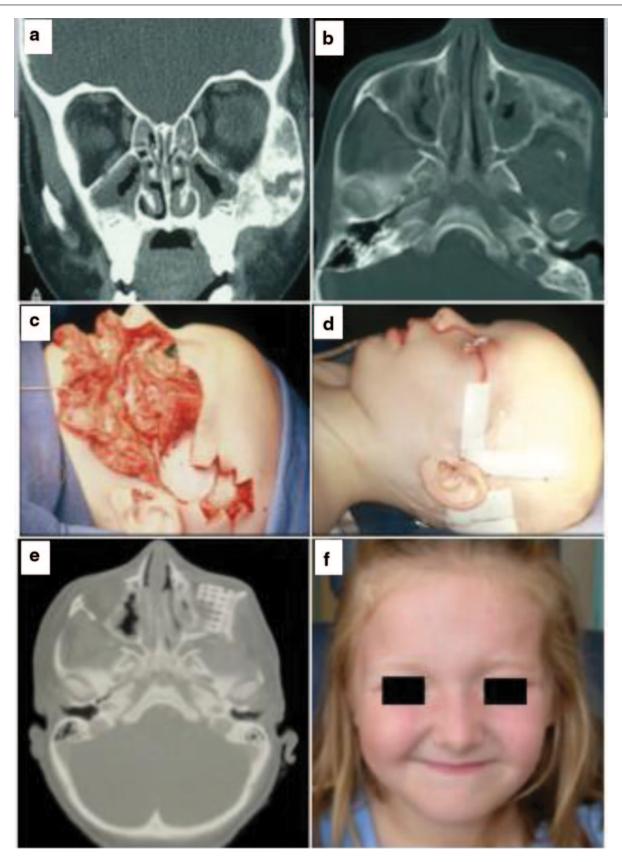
Axial (a) and sagittal (b) CT images of the paranasal sinuses of a 4-year-old female who is status-post chemotherapy for an embryonal rhabdomyosarcoma of the *left* maxilla and lateral wall of the *left* orbit. Using a modified Weber–Ferguson incision, the tumor was removed en-bloc with preservation of the *left* facial nerve (c). The closed
